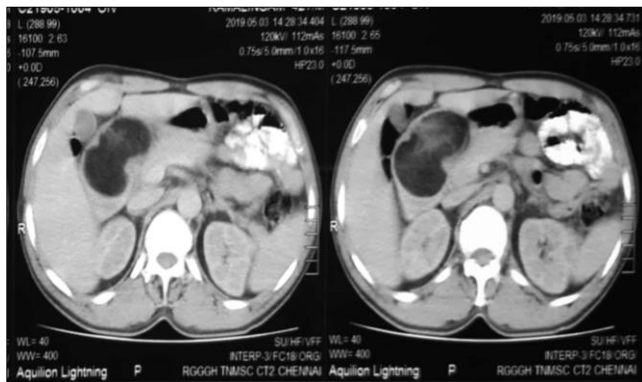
Contrast enhanced CT scan of abdomen showed a non-enhancing fat containing lesion in antropyloric region of stomach.
